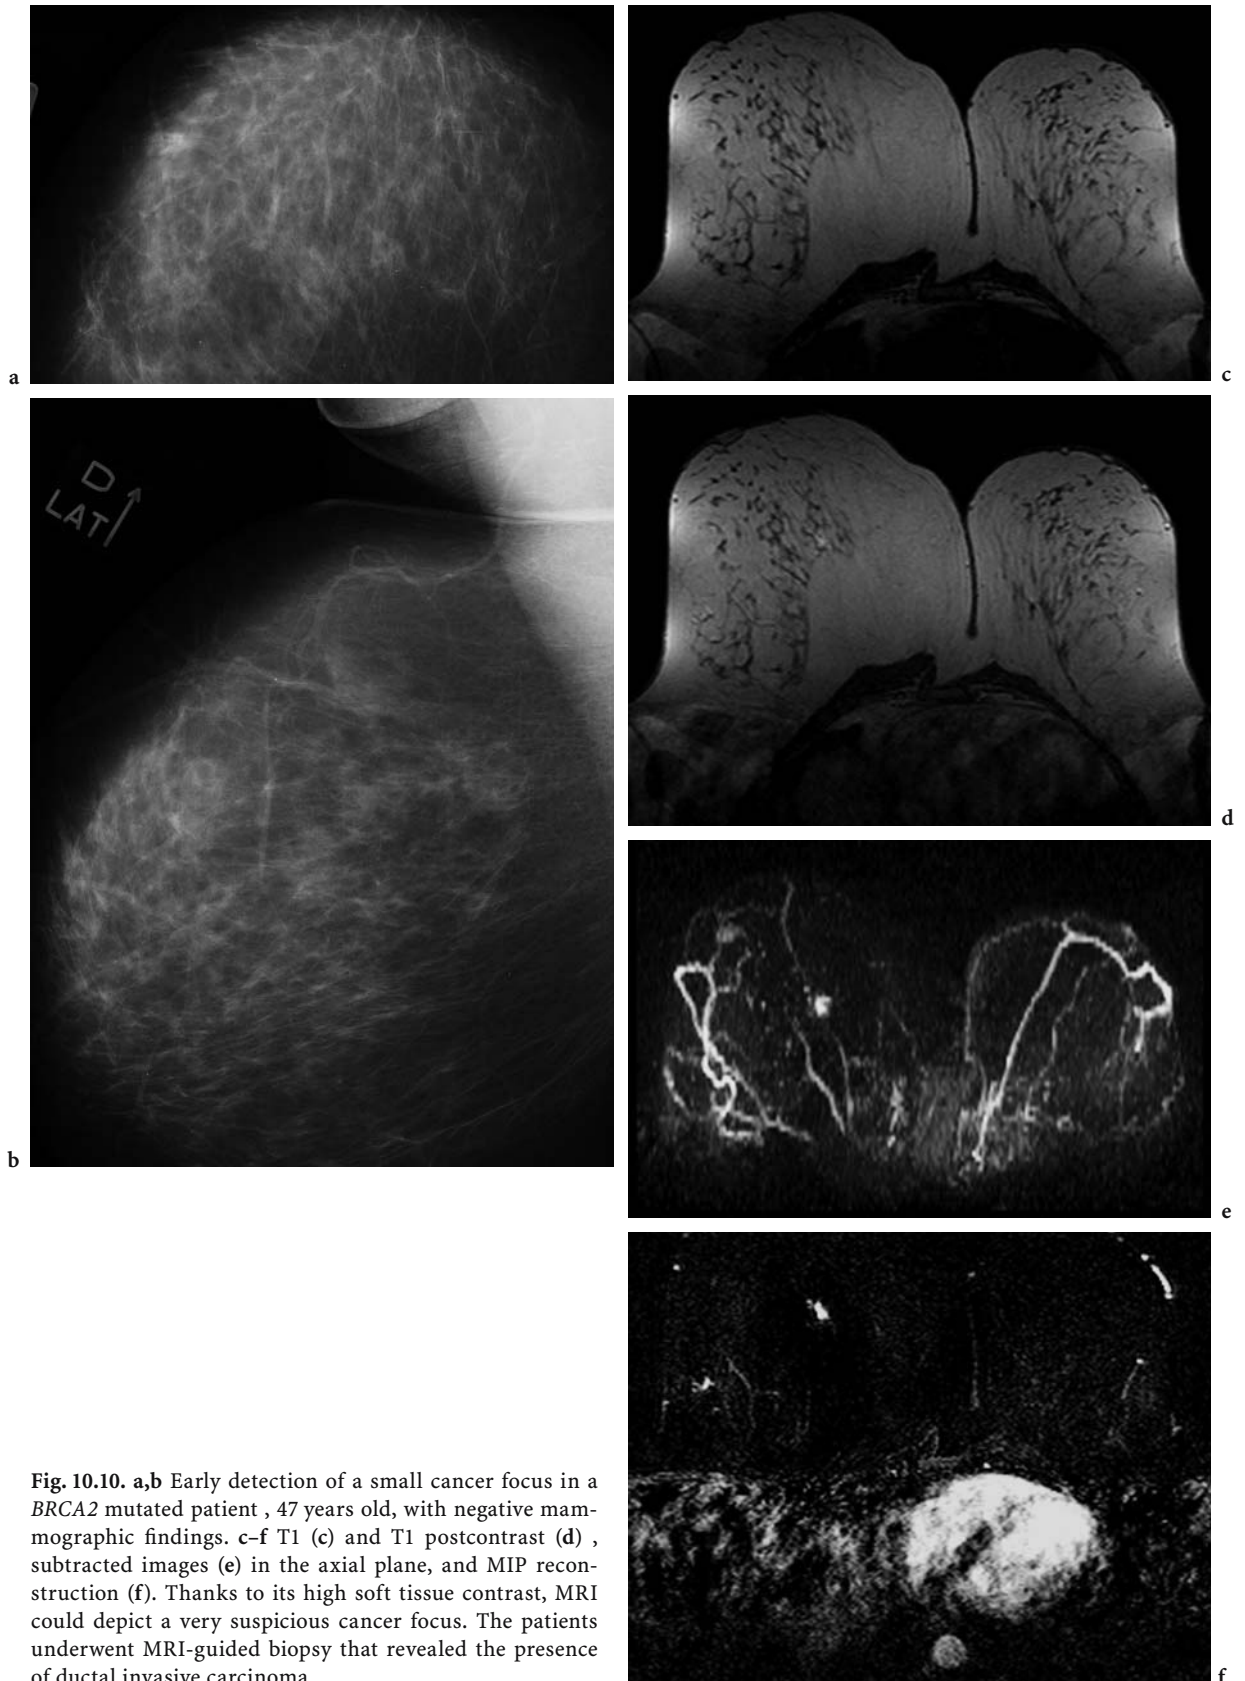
a,b Early detection of a small cancer focus in a *BRCA2* mutated patient , 47 years old, with negative mammographic findings. c-f T1 (c) and T1 postcontrast (d) , subtracted images (e) in the axial plane, and MIP reconstruction (f). Thanks to its high soft tissue contrast, MRI could depict a very suspicious cancer focus. The patients underwent MRI-guided biopsy that revealed the presence of ductal invasive carcinoma
